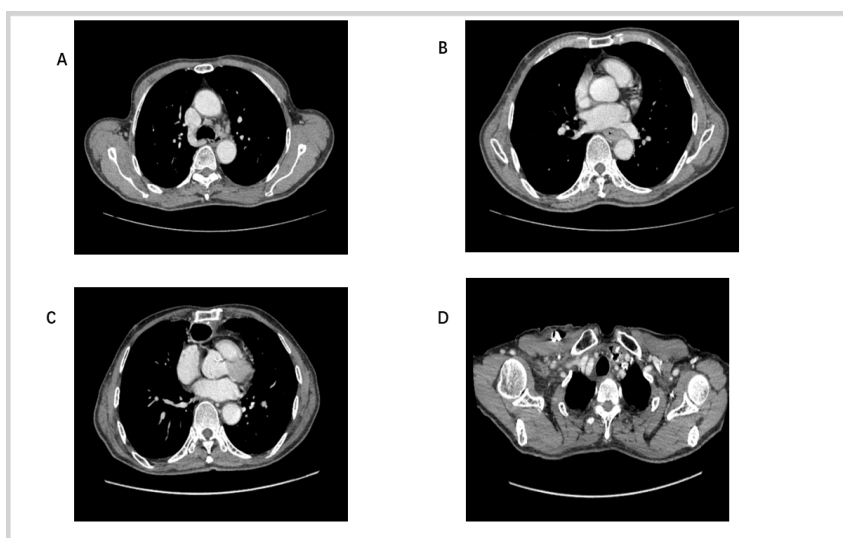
Preoperative and postoperative CT images of the patient. Panels A and B show preoperative CT images, while Panels C and D show postoperative CT images.
